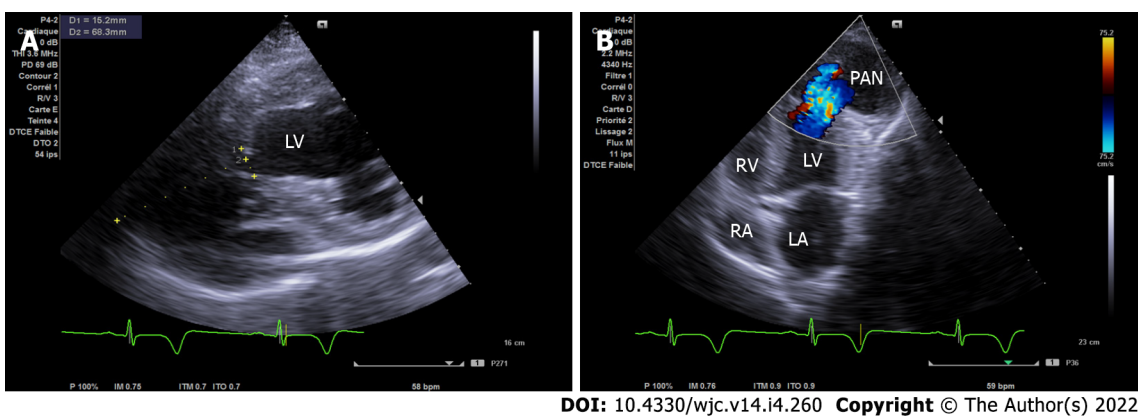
Transthoracic echocardiogram. A: Modified short axis view with the pseudoaneurysm dimensions (width of the neck was 15 mm and the maximal internal diameter of the aneurysmal sac was 68 mm with a neck to sac ratio of less than 0.5); B: Apical modified 4/5 chamber view showing bidirectional shunt through the left ventricular wall.
